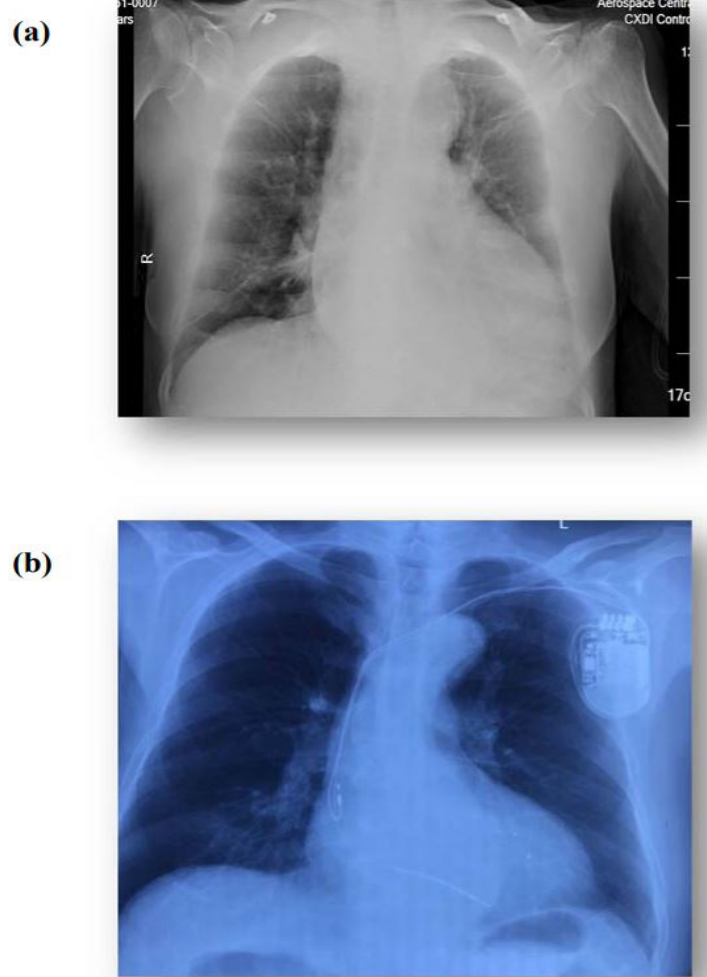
(a) The patient's chest x-radiography revealed pulmonary congestion, pear-shaped heart, and cardio-thoracic proportion more than 50% at baseline; (b) There was no pulmonary congestion, and the cardio-thoracic percentage decreased significantly, 30 days after the CRT-D implantation.
